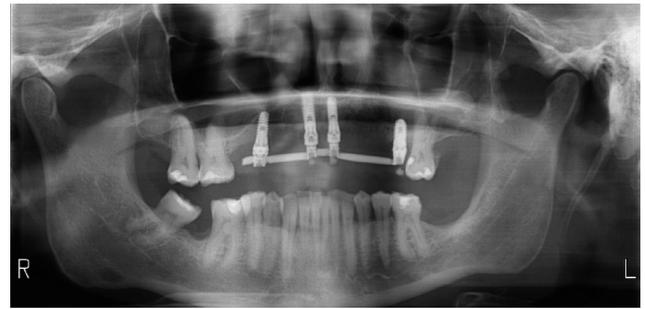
Panoramic x-ray after a year and a half of the restoration.
